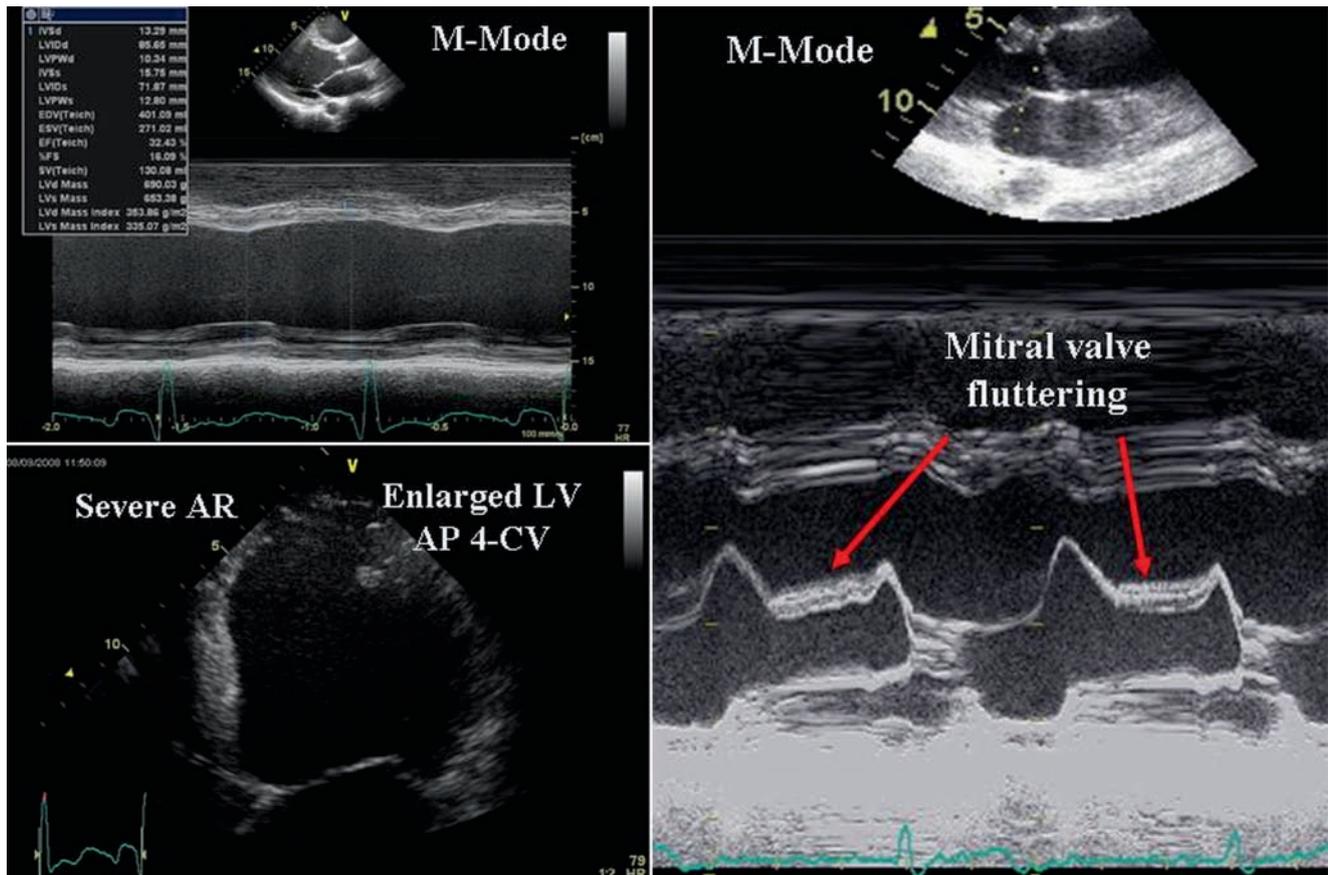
M-mode and 2D echocardiograms of the left ventricle and mitral valve showing an enlarged LV with decreased function and the fluttering motion (arrows) of the anterior mitral leaflet caused by significant AR. AP 4-CV; apical 4-chamber view
